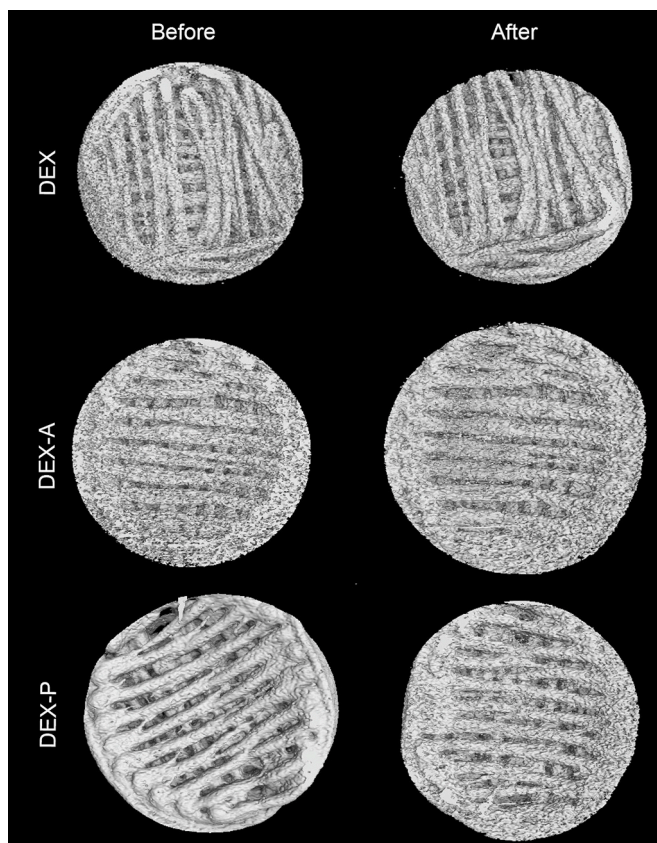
Visualisation of X-ray micro computed tomography (X μ CT) data for the top view of PRT before and after the dissolution studies.
